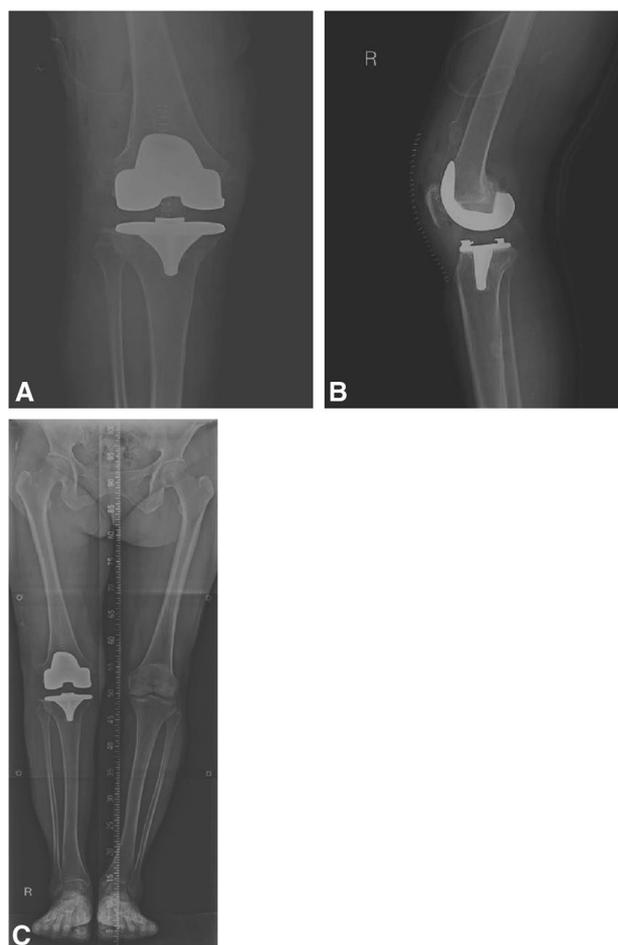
Postoperative AP (a) and lateral radiograph (b) right knee after primary TKA. c Postoperative scanogram lower limbs showing align right limb
